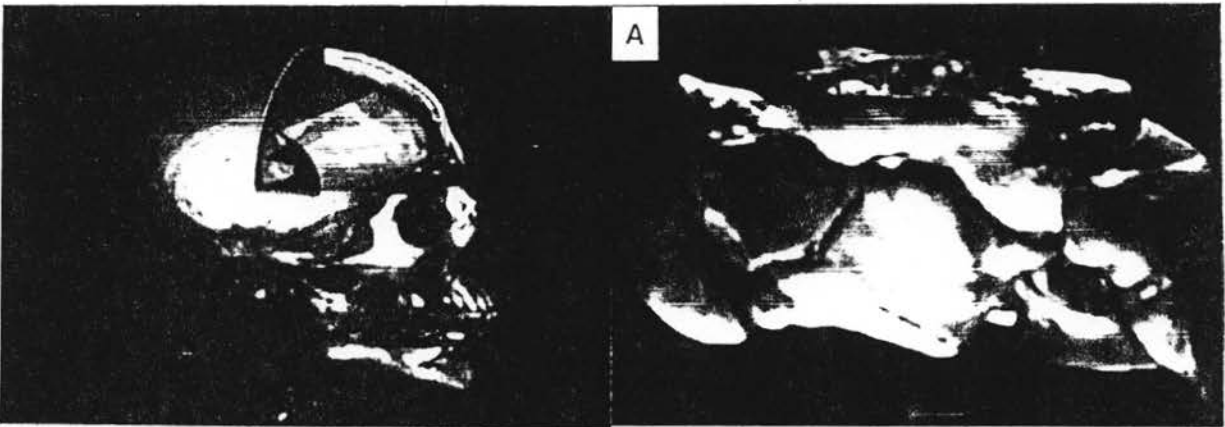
Polygonally tiled radiation treatment beam and tumor target in volume rendered head from CT.
